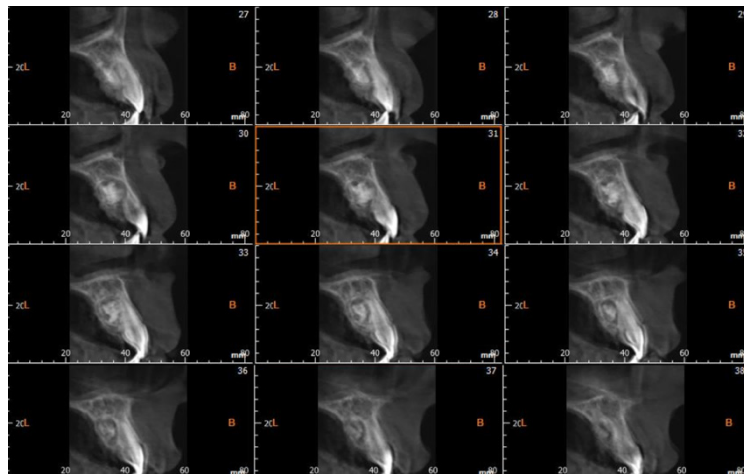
A CBCT view performed in order to define the extension of the lesion and the anatomical topography, showing the odontoma positioned palatally to the upper right permanent incisors.
